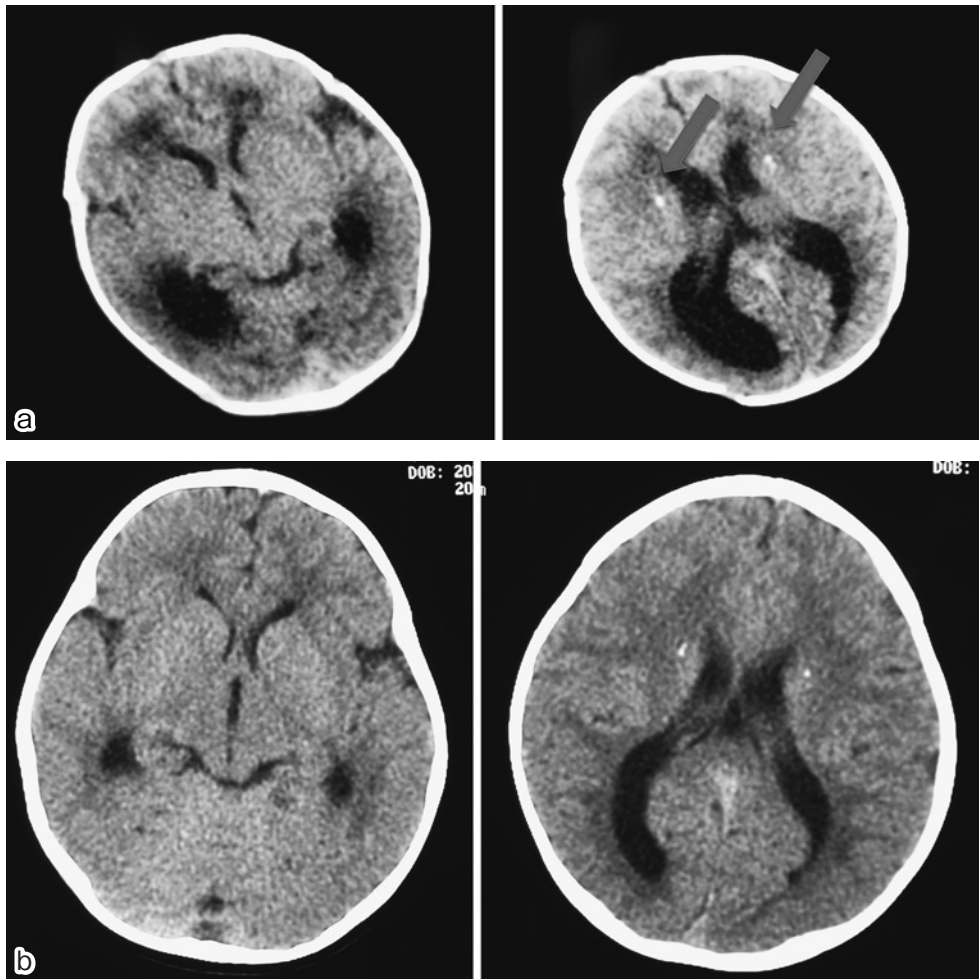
Computed tomography of the head
